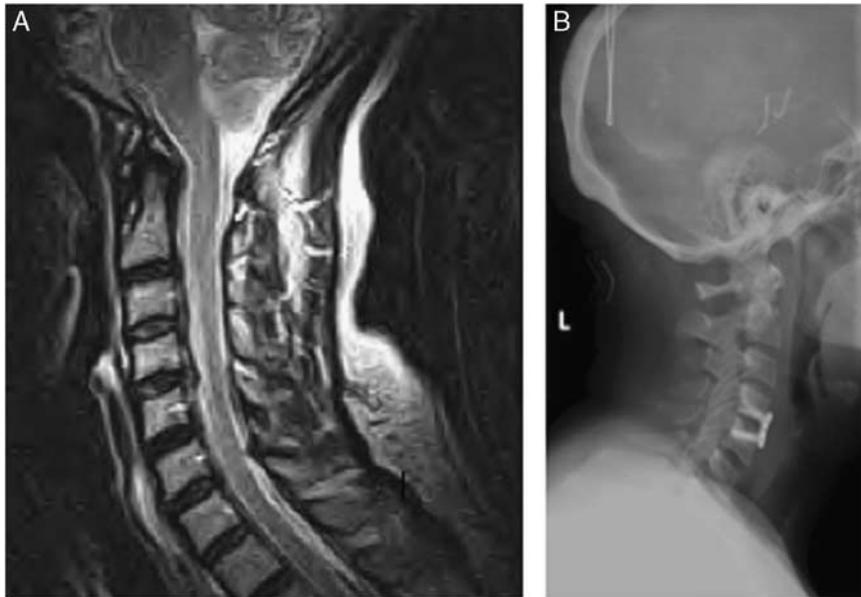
A and B, C4–C5 anterior cervical decompression and fusion (ACDF) done in the hospital setting. A, Preoperative magnetic resonance imaging (sagittal view) showing herniated C4–C5 disc. B, Two-week postoperative plain radiograph (lateral view).
